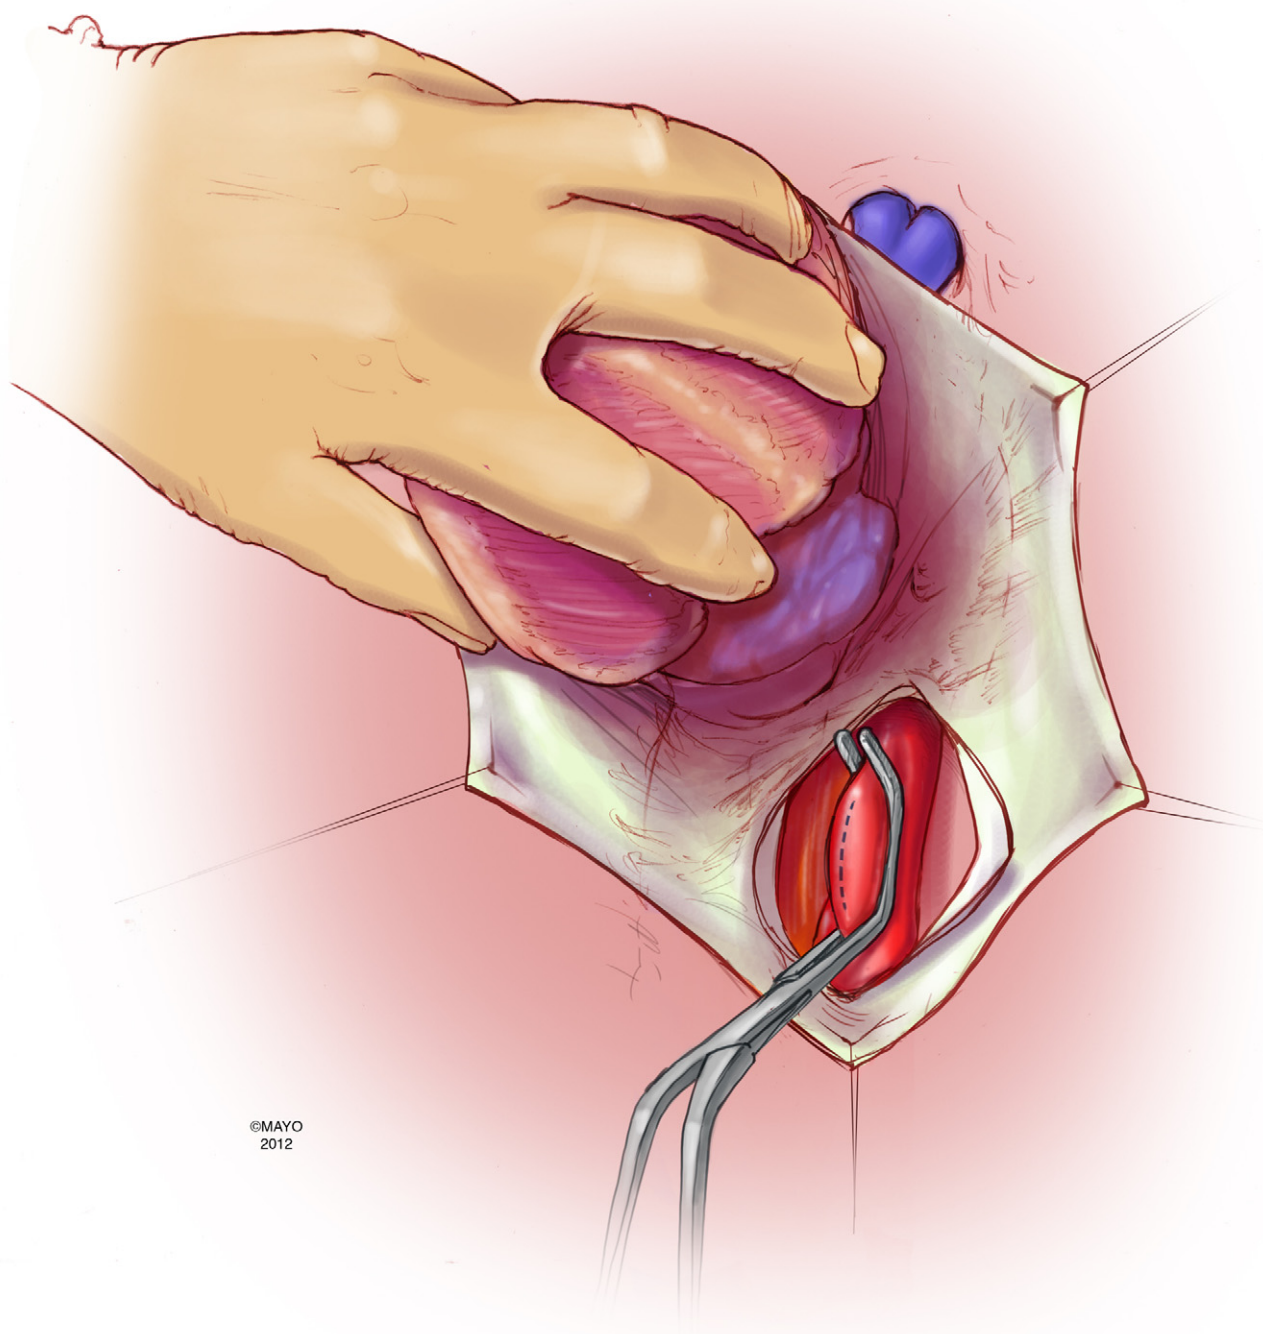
The heart is elevated out of the pericardial well and into the right hemithorax. A longitudinal incision is made in the posterior pericardium, exposing the descending thoracic aorta just cephalad to the diaphragm and leftward of the esophagus. Attention should be given to the nearby esophagus, which can be identified by the transesophageal echocardiography probe or a nasogastric tube. (Used by permission of Mayo Foundation for Medical Education and Research. All rights reserved.) (Color version of figure is available online at <http://www.optechtc.com>.)
